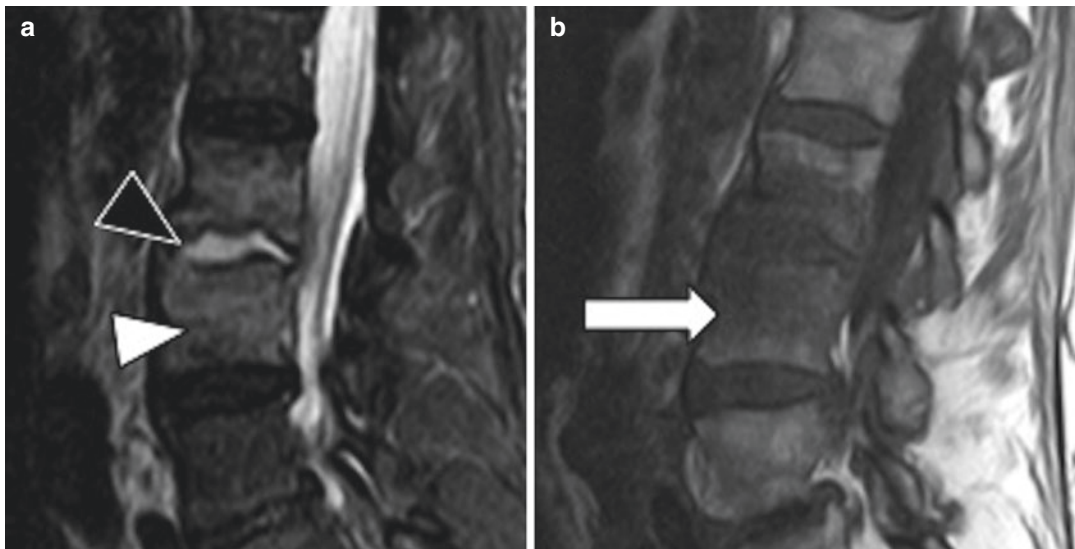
A 56-year-old male with L2–L3 pyogenic spondylodiscitis. Sagittal STIR fat-saturated MR image (a) demonstrates diffuse hyperintense signal >50% of the vertebral body height (white arrowhead) and uniform
